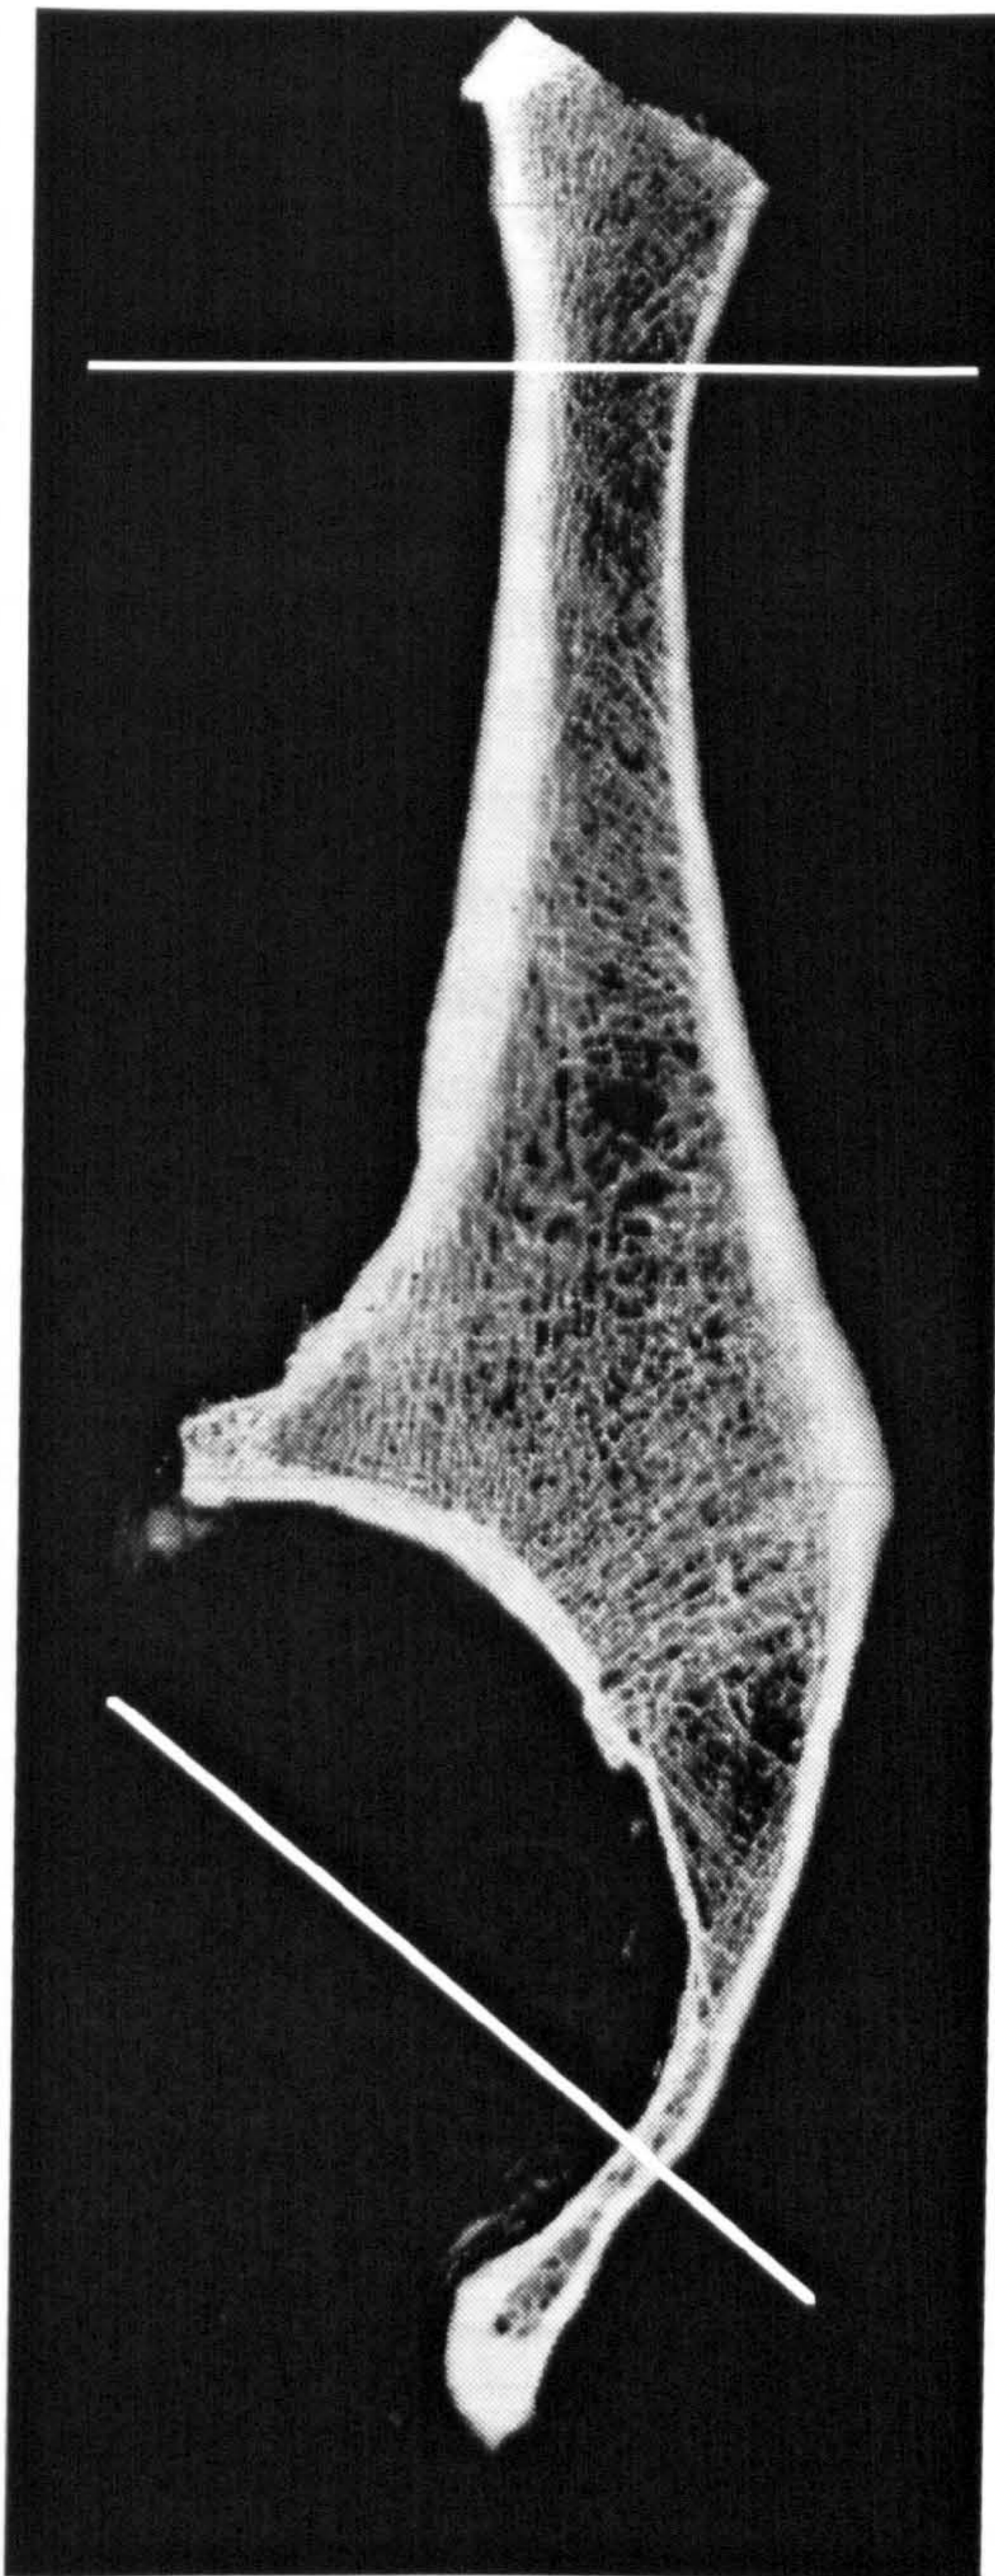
Roentgenogram of the model slice of Vasu et al (1982), showing trabecular orientation.
